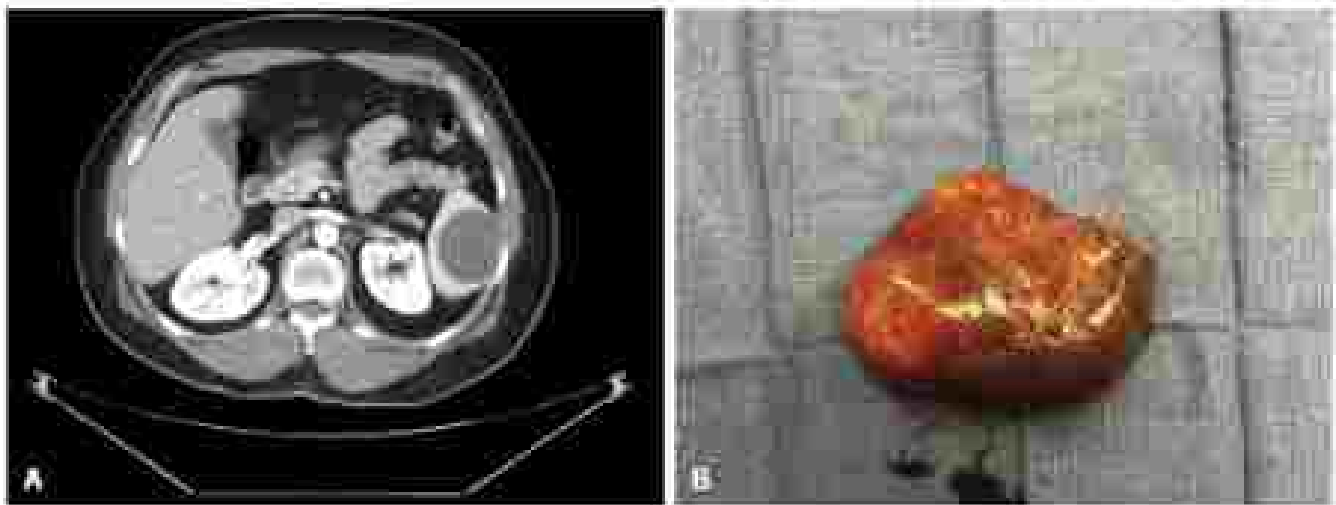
(A) Patient with a symptomatic splenic cyst found on computed tomography. (B) The spleen was removed with the cyst intact.
